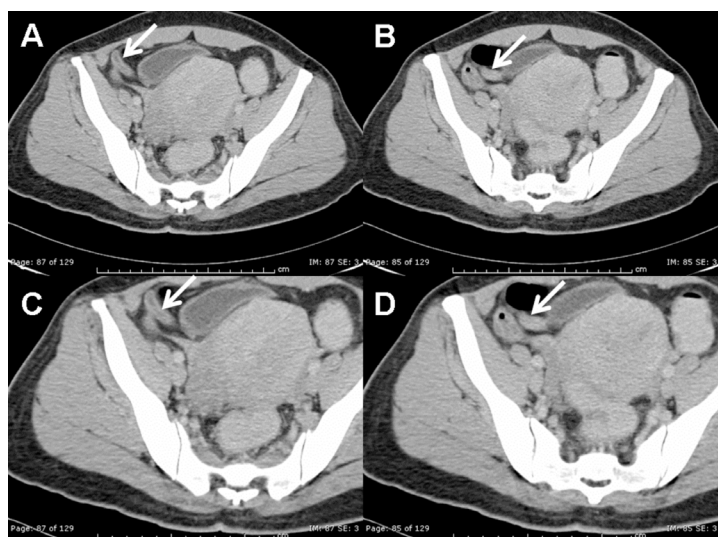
CT abdomen demonstrates a thickened and enhanced wall vermiform appendix (arrow), measuring 9 mm in diameter. There is mild periappendiceal fat reticulation and fascial thickening. A, B, non-contrast axial CT; C, D, post-contrast axial CT.
